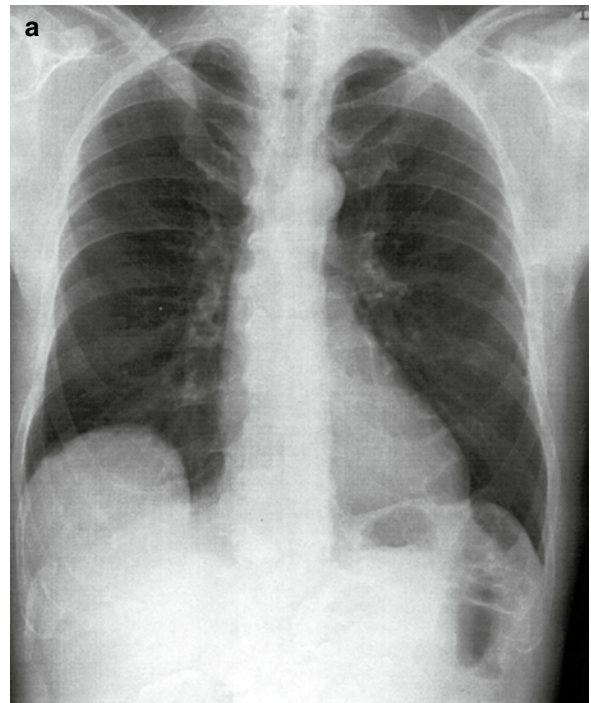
Rare finding of a diaphragmatic lipoma. Incidental finding. The smoothly delineated tumor (arrow) presented similarly on computed tomography
